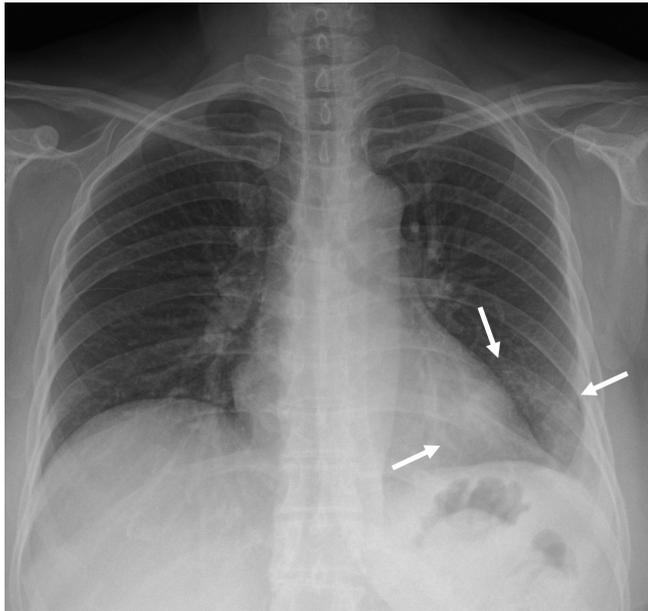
Plain chest radiograph shows patchy increased opacity in left lower lung zone (arrows) and small amount of left pleural effusion.
